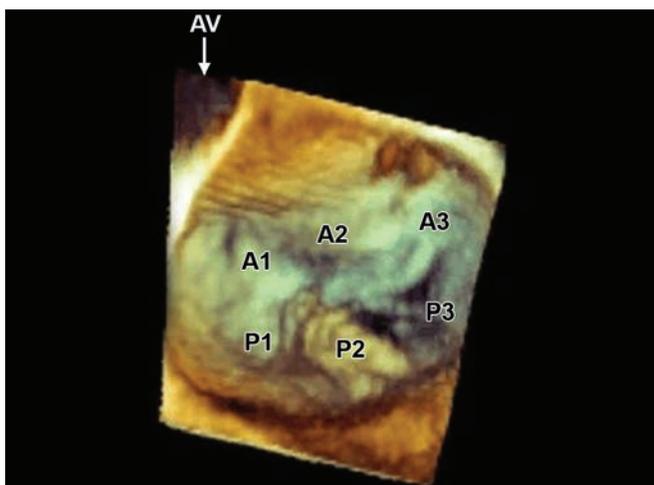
Three-dimensional transesophageal echocardiographic view of the mitral valve demonstrating the mitral valve scallops in systole with P2 and P3 scallop prolapse. (AV: Aortic valve; A1, A2, A3: Scallops of the anterior mitral leaflet; P1, P2, P3: Scallops of the posterior mitral leaflet).
